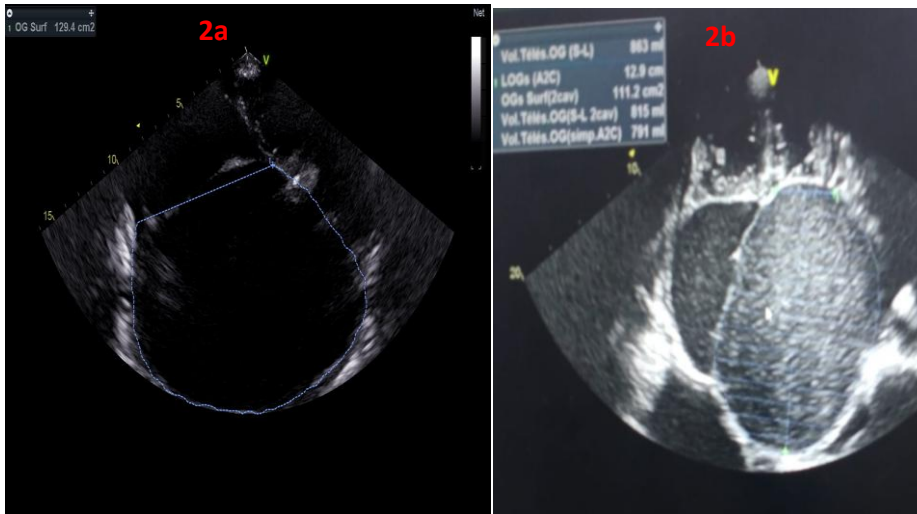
Transthoracic echocardiography (TTE): 4 chambers apical view: showing a giant left atrium (ectasia) occupying the whole monitor screen with a surface area of 129.4cm<sup>2</sup>.
